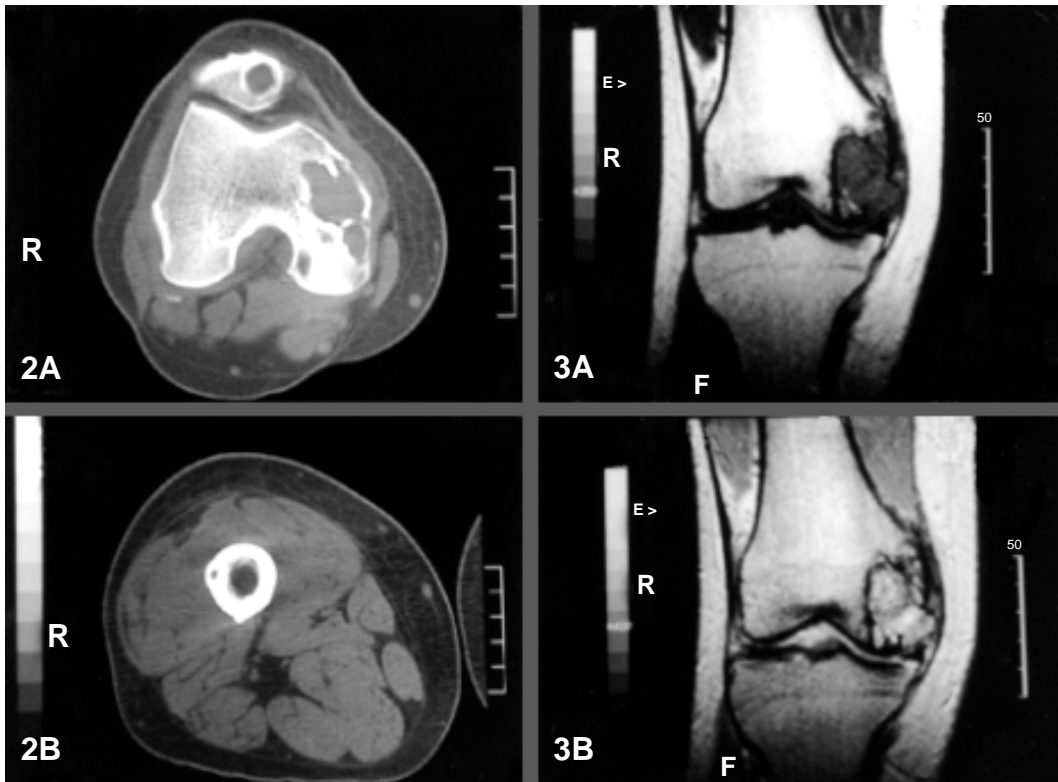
Computed tomography (CT) scans. A: Well-defined, osteolytic lesions with a thin sclerosing margin in the right femur and the patella. B: Intracortical lesion of the right fibula.
